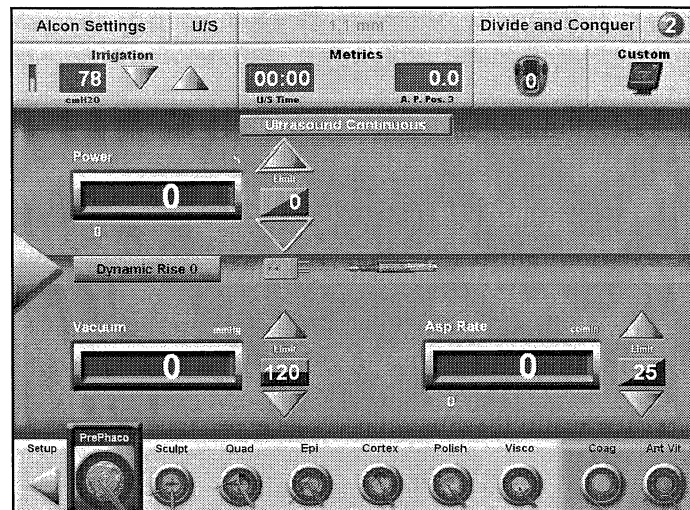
The Ultrasound Continuous Surgery Screen
